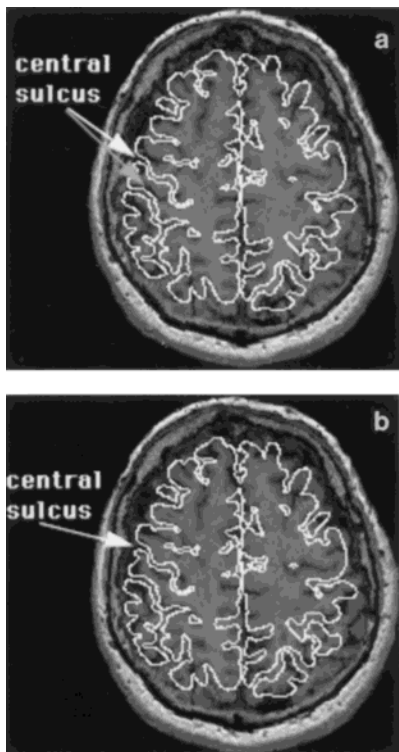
A cross-section from the top of the brain including the central sulcus. The cross-section in (a) is from the warped MR image using only homothetic mapping. The cross-section in (b) is from the warped image using homothetic mapping followed by curvature-based matching of the central sulcus and the interhemispherical fissure. A considerable improvement in the region around the central sulcus is apparent. Note that besides the central sulcus, the pre- and postcentral sulci and adjacent gyri are also aligned much better in (b) than in (a).
